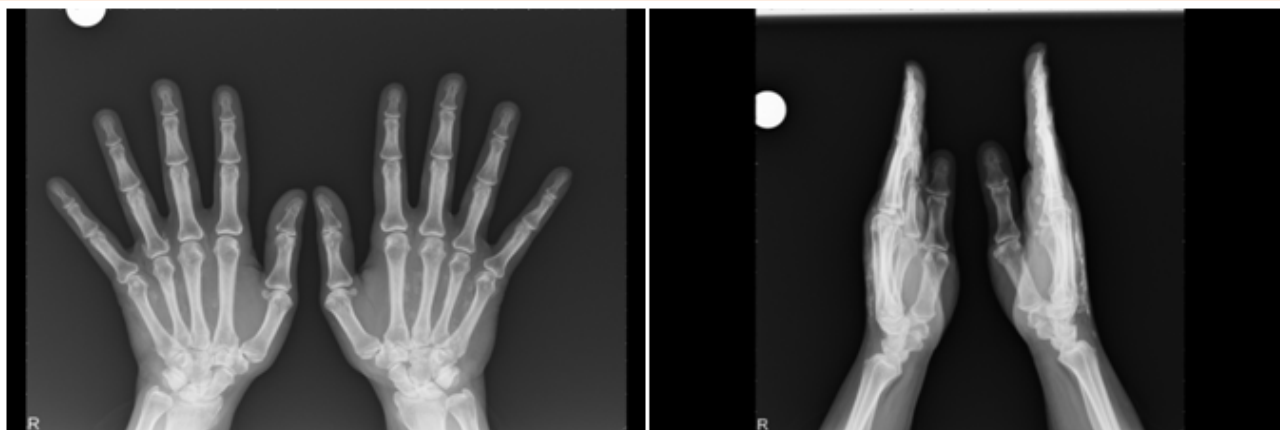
X-ray of both hands of 51 years old woman showing calcification of the soft tissues 5 years after injection of collagen into the web spaces.
